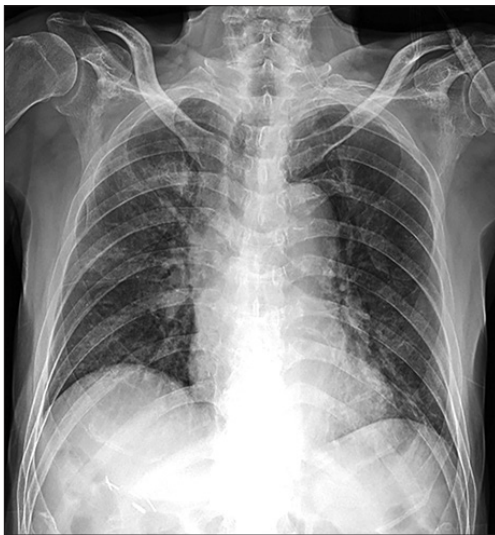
Anteroposterior chest radiograph obtained on March 26, 2020 (hospital day 1), showing diffuse peribronchial infiltration in the parenchyma of both lungs.
